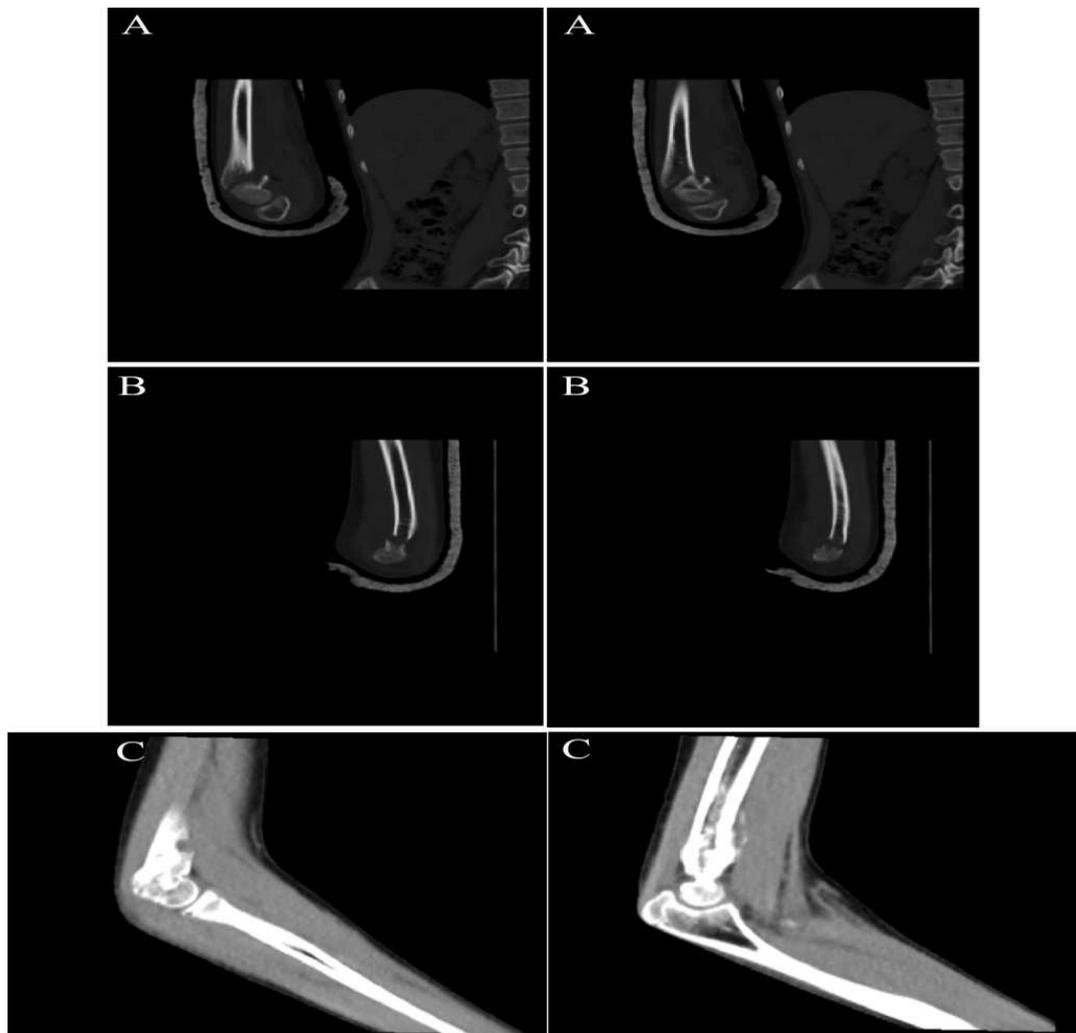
CT examination pictures of a child with right humeral supracondylar fracture (A) Pre-administration CT scan: Obvious fracture line was observed, with clear boundary between fracture fragments; (B) During-administration CT scan: Fracture line remained visible; (C) Post-administration CT scan: Fracture line was significantly blurred, indicating progressive union.
